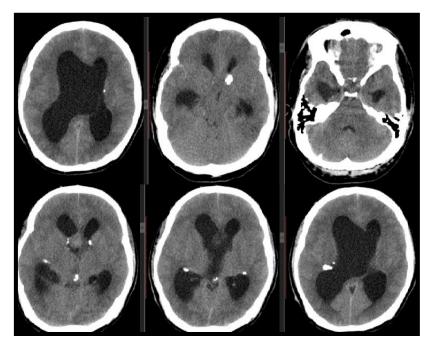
Plain and contrast-enhanced cranial CT scan in axial view. There is a homogenously enhancing intraventricular mass measuring $1.3 \times 1.5 \times 1.4 \text{ cm} (\text{CC} \times \text{W} \times \text{AP})$ noted just above the third ventricle, more on the right. The lateral ventricles were dilated. There is no dilatation of the third and fourth ventricles. Multiple calcific (hyperintense) subependymal nodules are evident.
